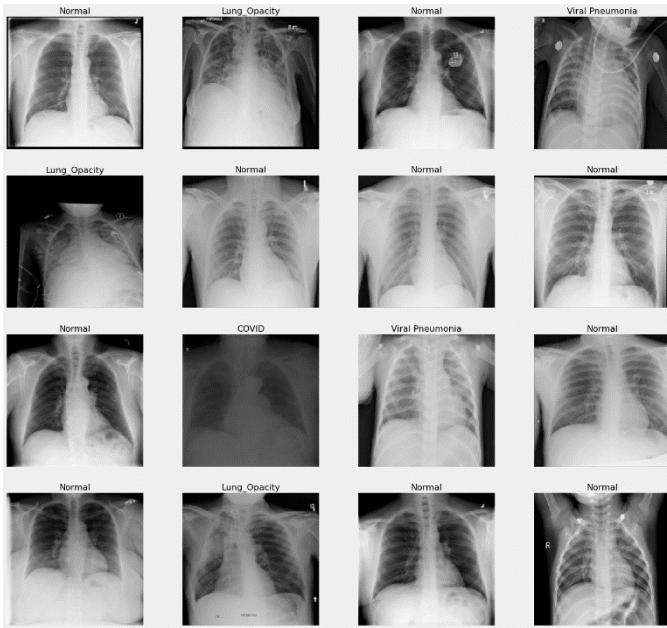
Cases of chest X-ray images of for classes from Kaggle dataset.
